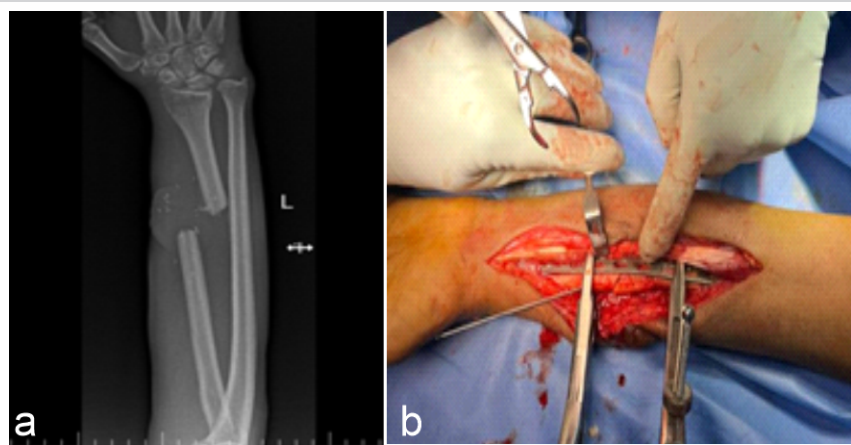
Pre-operative X-rays of distal 1/3rd radius fracture with 3 cm bone loss.
